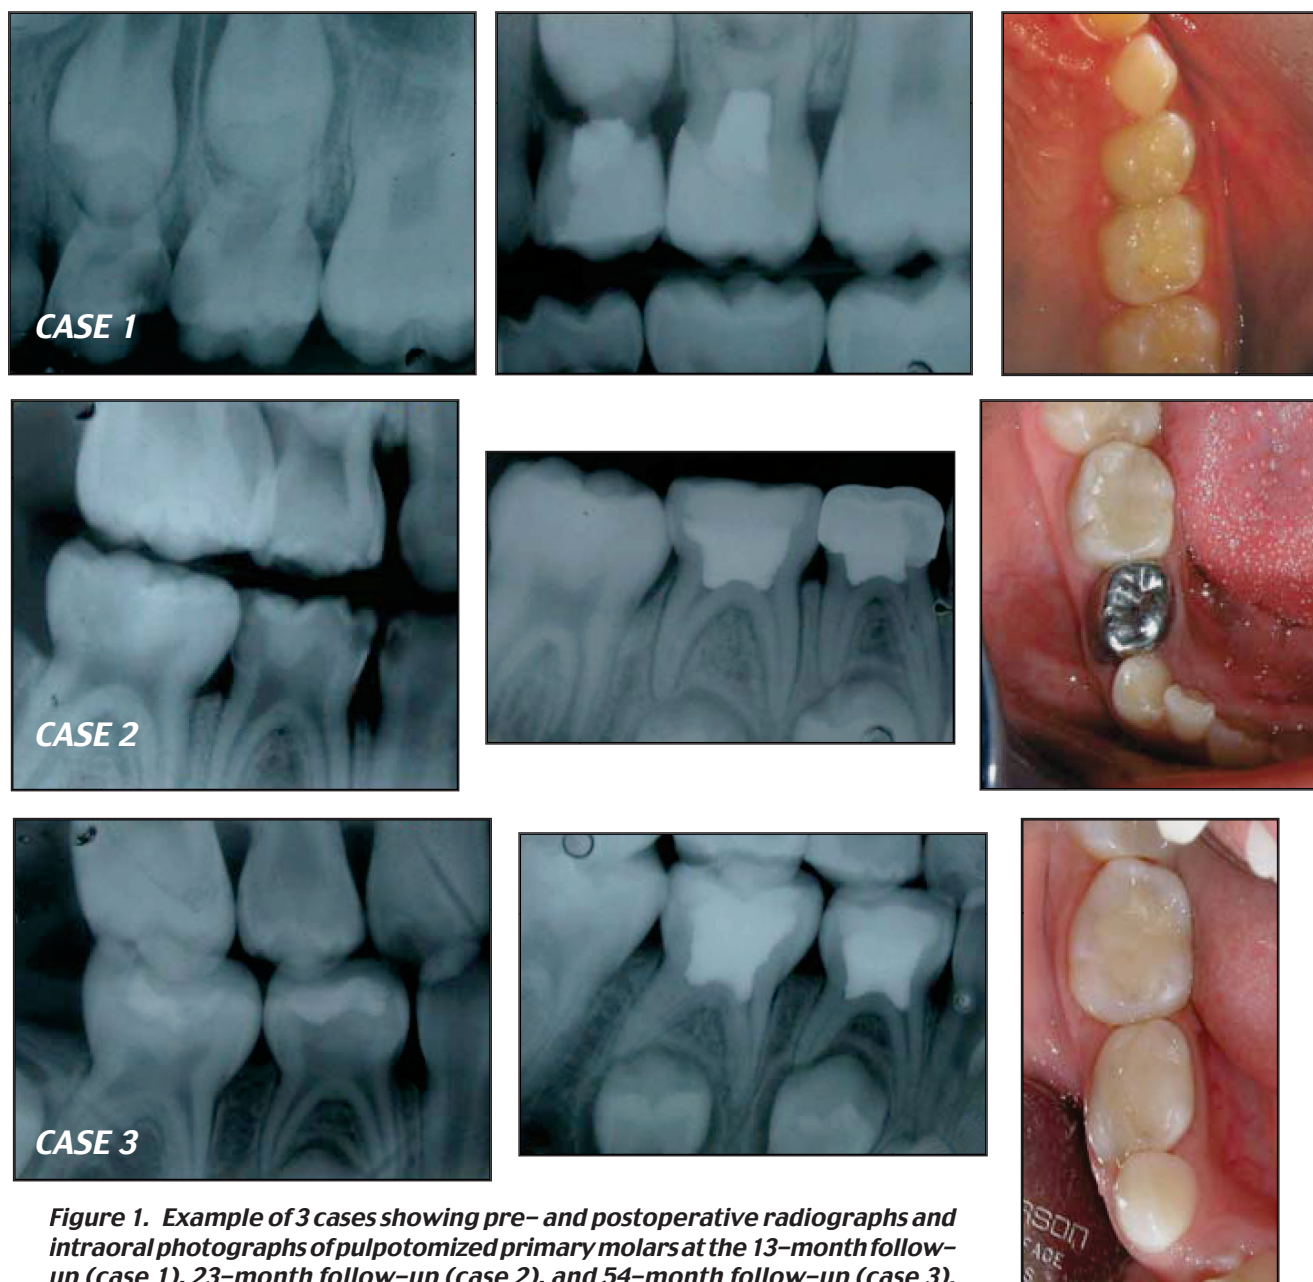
Example of 3 cases showing pre- and postoperative radiographs and intraoral photographs of pulpotted primary molars at the 13-month follow-up (case 1), 23-month follow-up (case 2), and 54-month follow-up (case 3).
